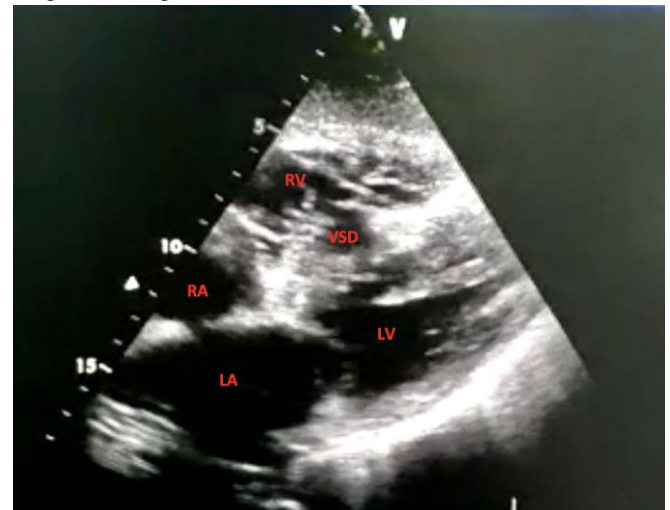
Transthoracic echocardiography in subcostal view showing ventricular septal defect. VSD: ventricular septal defect, LV: left ventricle, RV: right ventricle, LA: left atrium, RA: right atrium.
